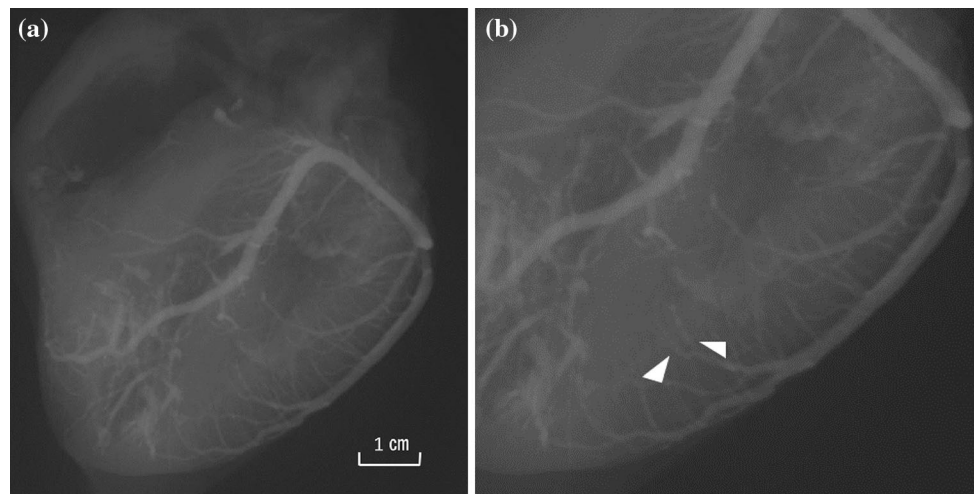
An excised heart irradiated by the conventional X-ray system with a 20-cm-thick acrylic plate. a The image was obtained by the conventional X-ray system set at 100 kV, 50 mA, and 1000 ms of tube voltage, current, and exposure time, respectively, after placing a
